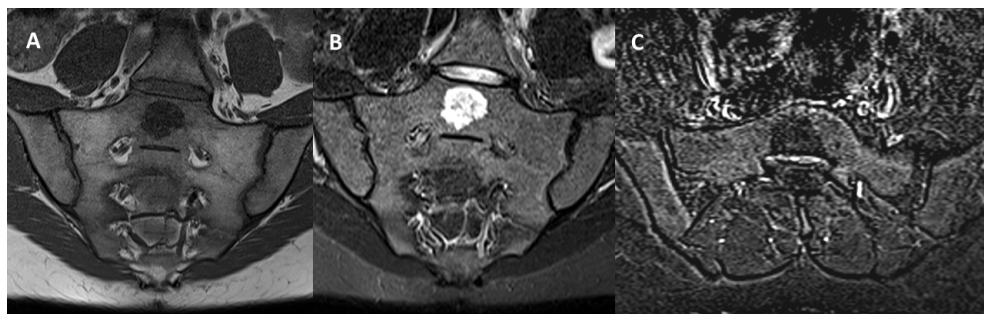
Coronal oblique T1-weighted (A), STIR (B) and axial oblique T1 fat saturated post-contrast subtraction (C) MRI images demonstrate a lesion in the midline of the S1 vertebral body with heterogeneous T2 hyperintensity and T1 hypointensity. No evidence of post-contrast enhancement or surrounding edema was observed.
